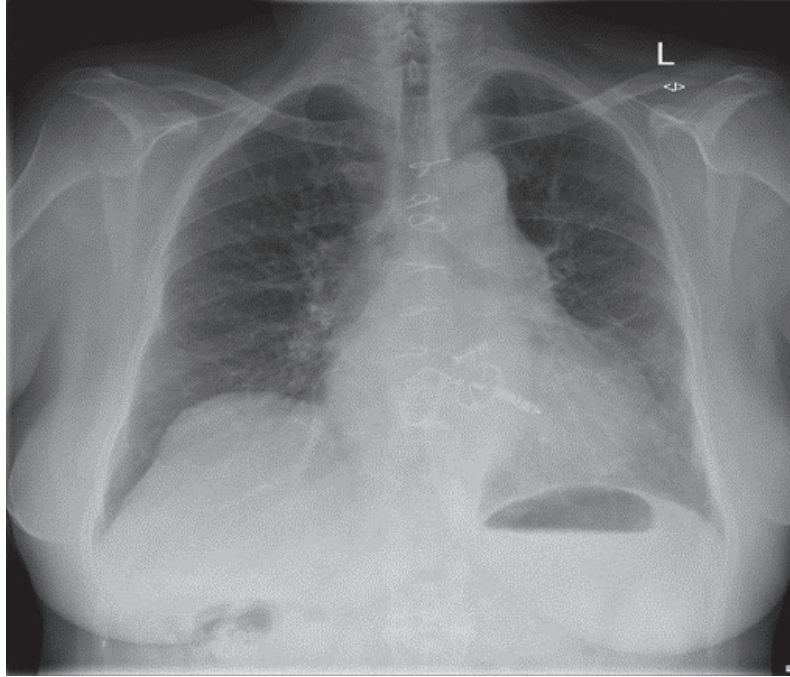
Chest X-ray, PA projection. Placement of the MICRA TPS pacemaker in the heart; visible valve rings: aortic, mitral and tricuspid
